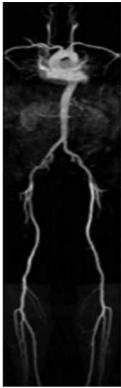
Maximum intensity projection of whole-body MRA shows all the arteries from the head to the leg, which are used to calculate the atherosclerotic score index. (Modified from Lehrke S. Egenlauf B. Steen H. et al: Prediction of coronary artery disease by a systemic atherosclerosis score index derived from whole-body MRI angiography. J Cardiovasc Magn Reson 11:36, 2009.)
